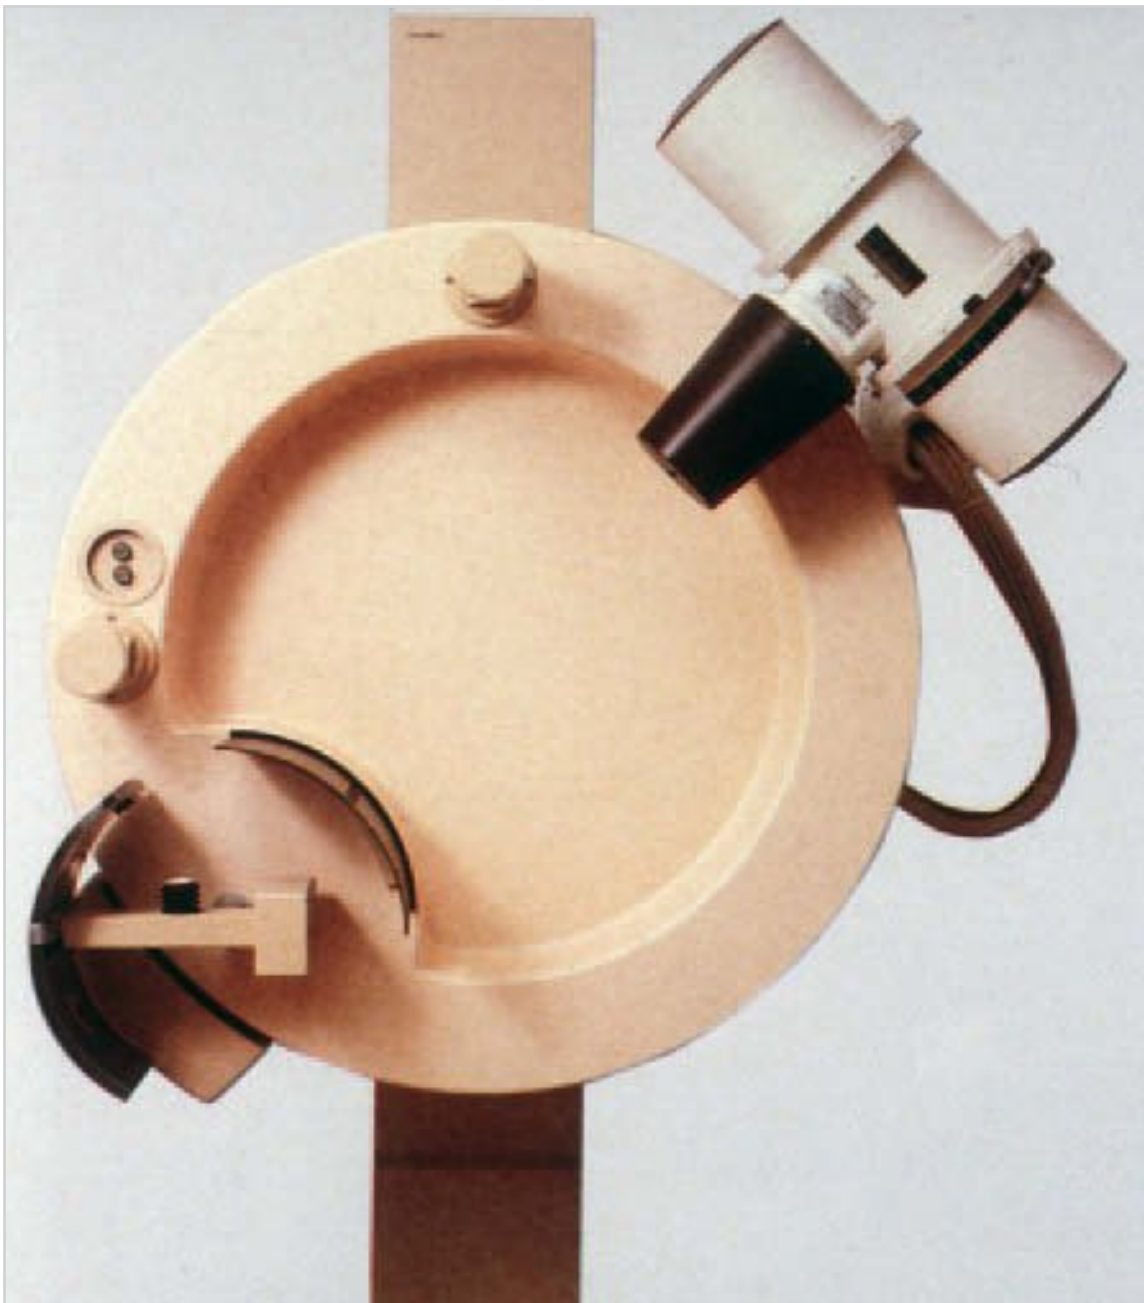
The Zonarc rotational panoramic radiography machine for recumbent patients has several special programs.
